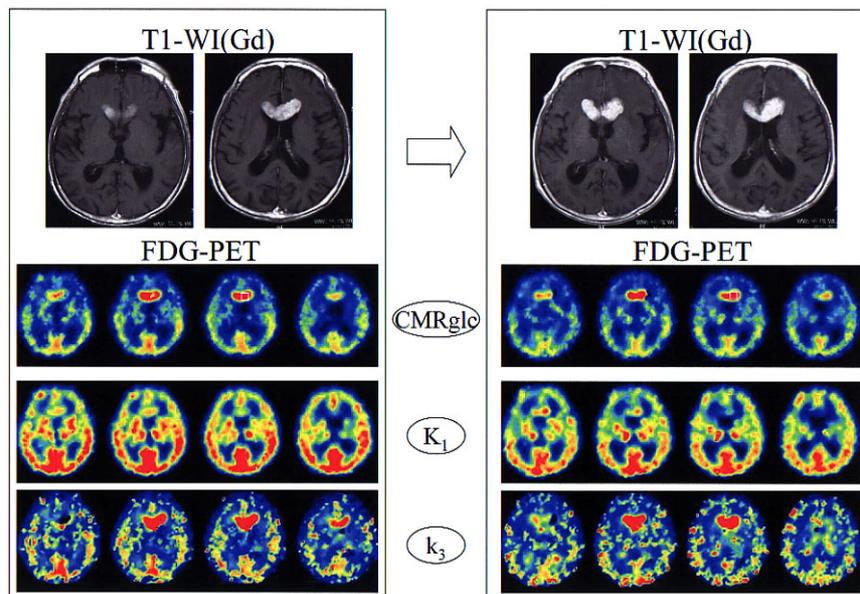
Axial MR and FDG-PET images before (*left panel*) and 15 days after (*right panel*) the chemotherapy in Case 7. Open squares indicate ROI for FDG-PET quantitative analysis. Before the chemotherapy, axial T1-weighted MRI with gadolinium showed a well-defined enhancing tumor in the corpus callosum. The tumor exhibited substantially high FDG uptake relative to surrounding brain on FDG-PET images. Corresponding lesion showed a markedly accelerated k_3 value in the tumor in the kinetic analysis. Fifteen days after the chemotherapy, the tumor volume was increased on gadolinium enhanced T1-weighted MRI and the neurological status of the patient deteriorated progressively. At the same time, the lesion showed still high FDG uptake on FDG-PET images with increased k_3 values similar to those obtained before the chemotherapy.
